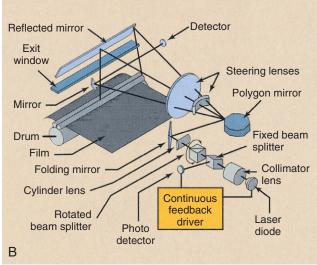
A, A thin film digitizer uses a laser beam to convert an analog radiograph into a digital image. B, The printing to film is similar to that of a laser printer. (A courtesy Agfa; B courtesy Imation.)
